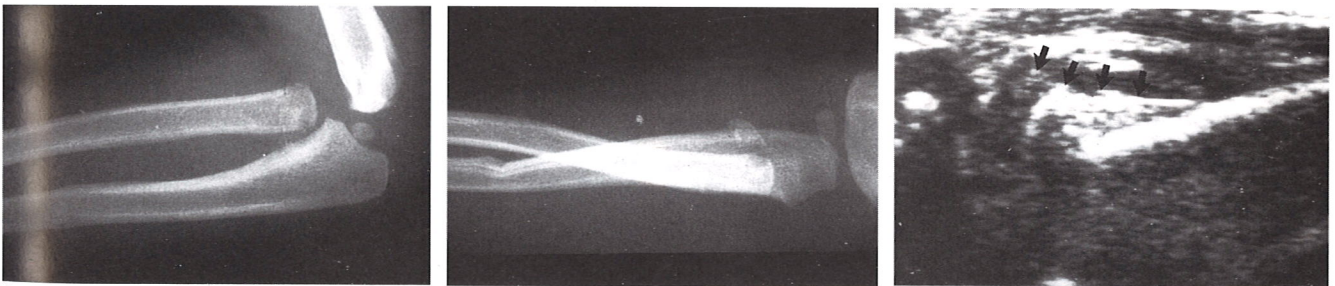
Left and center, On plain radiographs, this fracture in an 18-month-old child could be confused with a Monteggia lesion. Right, Ultrasound demonstrates normal articulation of the radial head with the capitellum, confirming the diagnosis of radial head fracture without dislocation. Arrows outline periosteum and radial head.
